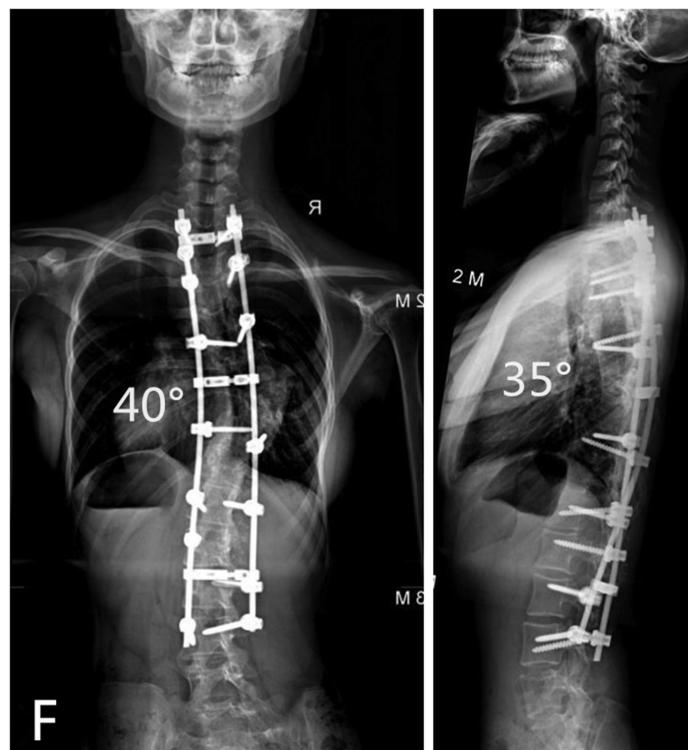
Postoperative long-standing scoliosis radiographs revealed good correction of severe and rigid spinal deformity, wherein the coronal main curve could be corrected to 40° and sagittal kyphosis curve to 35°.
